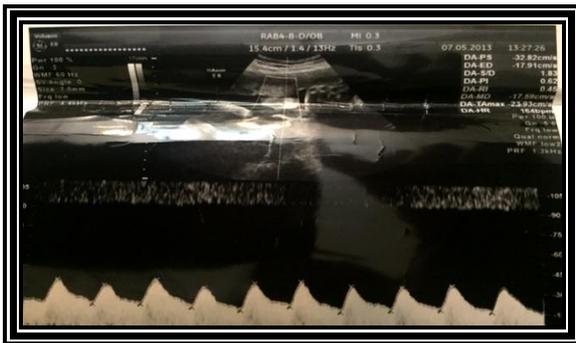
Dopplerometry. Blood flow in the umbilical artery.
